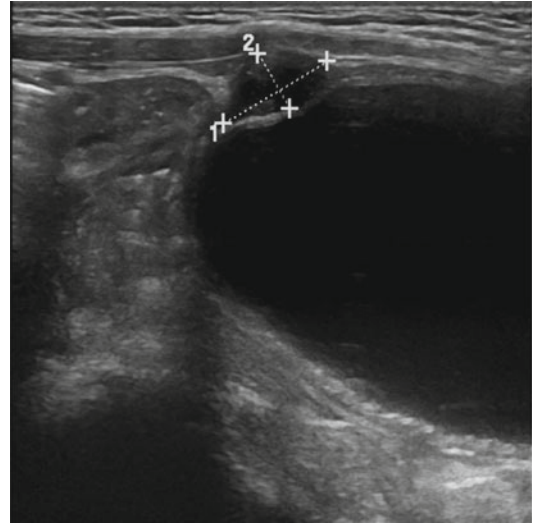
Ultrasound shows a urachal cyst as oval formations at the level of the mid-paramedian line, hypoechoic, that do not break the bladder parietal line
